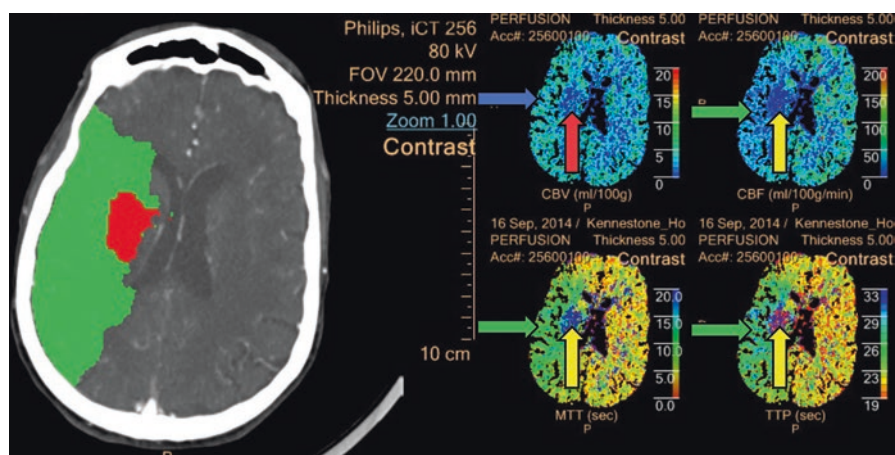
Relevant images of CT perfusion of the head. Left image is a computer reconstruction of the images seen on the left. Green area suggests area of salvageable tissue or penumbra and the red area suggests the area that has already gone to infarction and represents core infarct. Images on the right clockwise starting on the upper left corner: (Cerebral blood volume (CBV), Cerebral blood flow (CBF), Time To Peak (TTP) and Mean Transit Time (MTT)). Core infarct is identified as increase in TTP, MTT and a decrease in CBF (yellow arrows) as well as a decrease in CBV (red arrow). Penumbra is shown with increased TTP, MTT and a decrease in CBF (green arrows) as well as a stable CBV (blue arrow)
